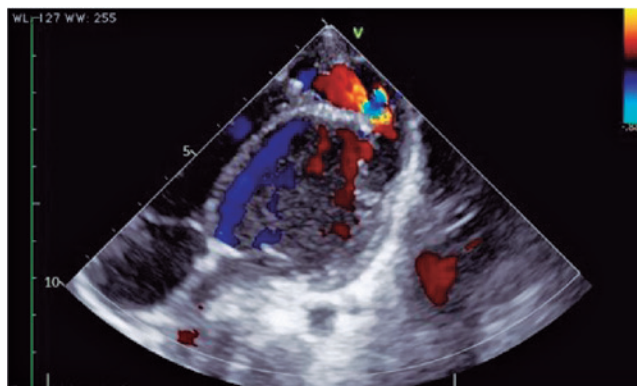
Transthoracic echocardiographic images showing the surgical patch and a leak at the end of the patch as demonstrated by color Doppler.
